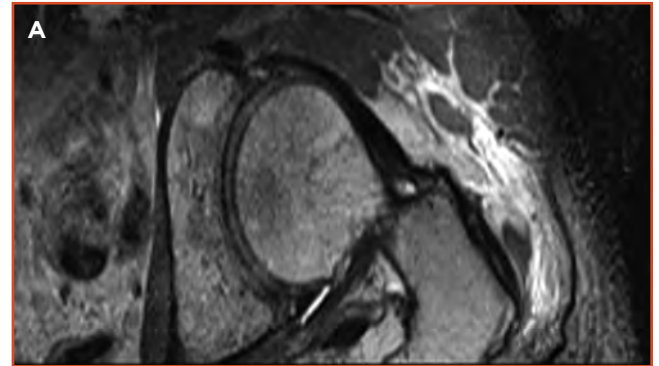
A) Axial and B) coronal magnetic resonance imaging of the left side of the hip, showing gluteus minimus and medius muscle edema consistent with an intramuscular tear.
